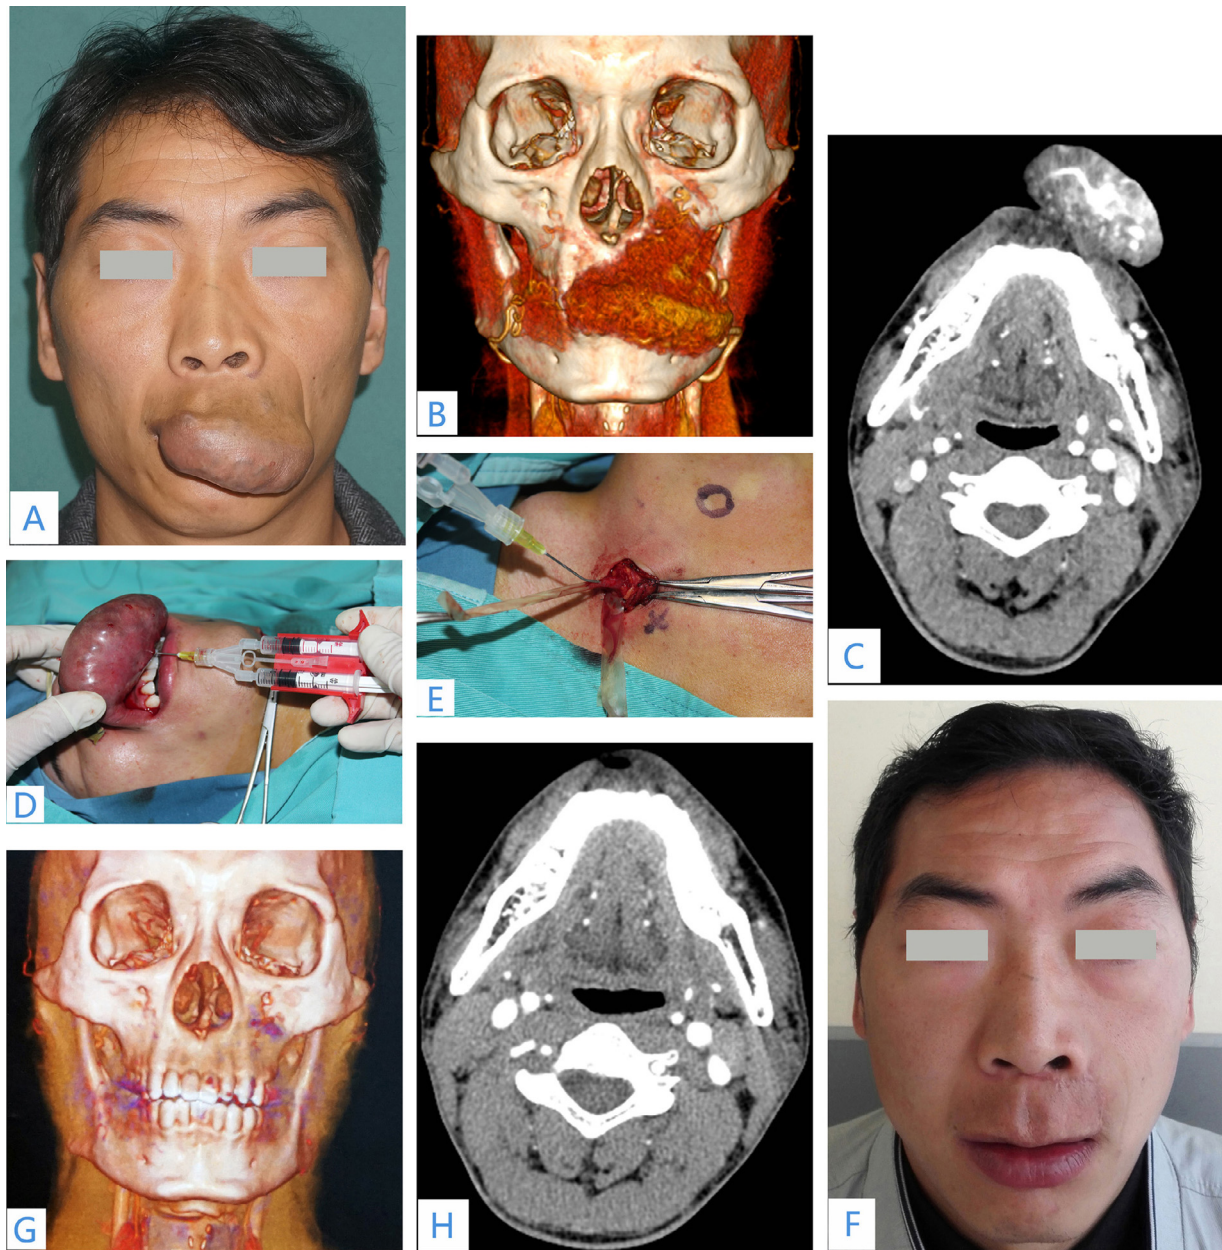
Arteriovenous malformation (AVM) in the upper lip and paranasal area. A–C, Facial appearance, 3-dimensional computed tomography angiography (3-D CTA) and computed tomography (CT) scans before treatment. D, Direct puncture and injection of fibrin glue (FG) combined with pingyangmycin (PYM). E, Injection of FG combined with PYM through external maxillary artery. F–H, Facial appearance, 3-D CTA, and CT scan after treatment.
